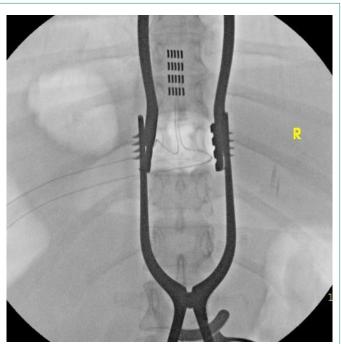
AP view fluoroscopic X-ray showing an implanted Abbott Medical Penta 3 mm Lead, 60 cm; SCS Paddle Lead. The image shows the paddle leads placed near the spinal cord. The "R" in the image indicates the right side of the patient.
